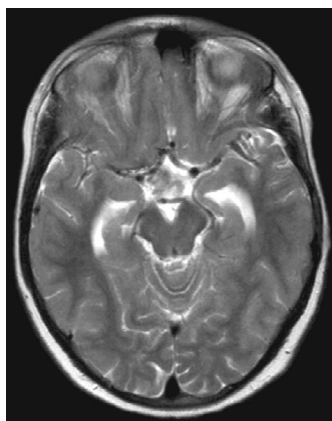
Axial T2-weighted MRI scan showing a residual tumor without inflammatory signs.
